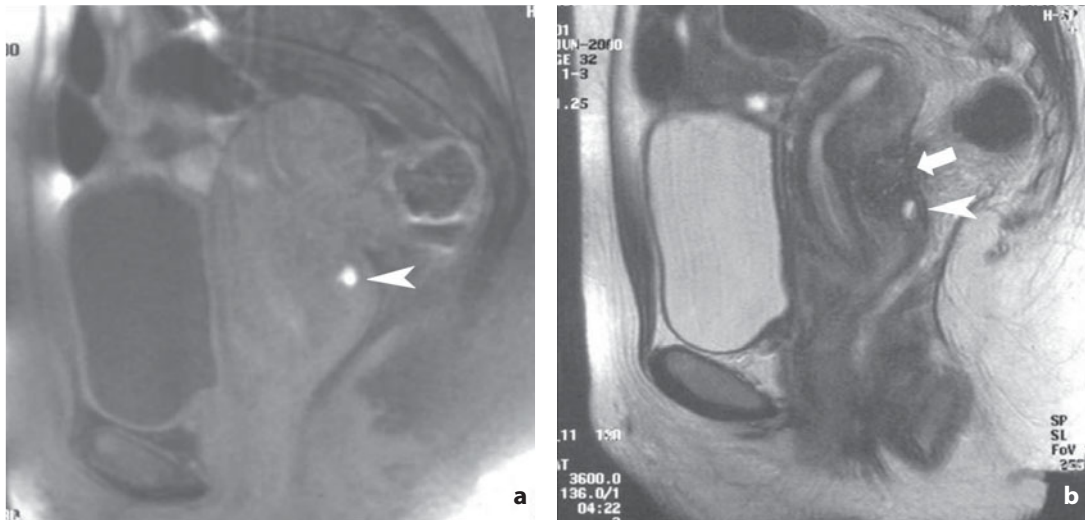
Magnetic resonance. Endometriosis of the posterior vaginal fornix. Straightened retroflex uterus. Small endometrial nodule in the posterior vaginal fornix (*arrowhead*) appears hyperintense in both the T1-weighted sequence with fat-signal suppression (a) and the T2-weighted sequence (b) in which the blood-fluid level is better identifiable. An adjacent plaque of uterine adenomyosis can also be seen (*arrow*)
